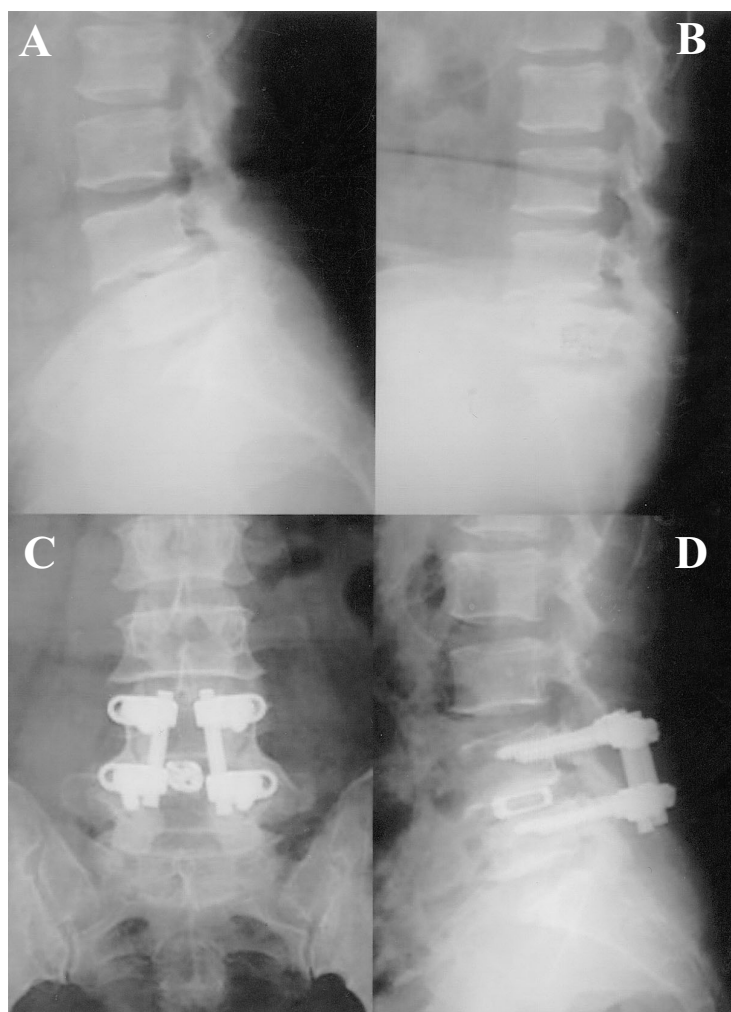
Pre-operative plain film of L-S spine, (A) flexion view; (B) extension view. Post-operative plain film of L-S spine; (C) antero-posterior view; (D) lateral view.
